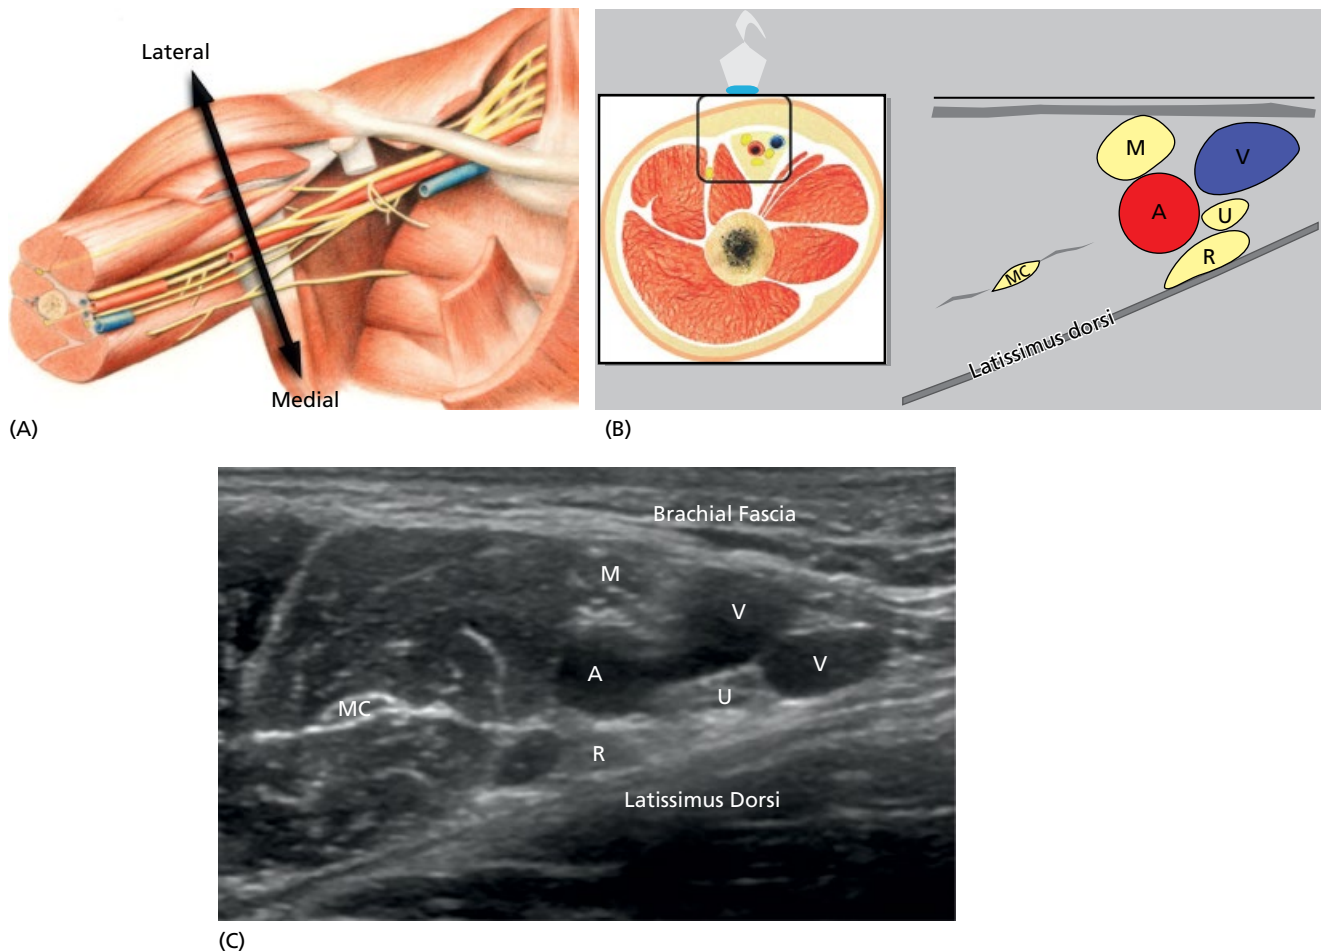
The axillary region. (A) Anatomy. (B) Ultrasound imaging. The ultrasound probe is depicted at the top of the left panel. The right panel is a magnified view. (C) Ultrasound image. The nerves are pictured as distinct hypoechoic nodules with internal hyperechoic punctuations typically situated lateral (median nerve), medial (ulnar nerve), and posterior (radial nerve) to the anechoic pulsatile axillary artery. A, axillary artery; V, axillary vein; MC, musculocutaneous nerve; M, median nerve; U, ulnar nerve; R, radial nerve. See text for further details.
